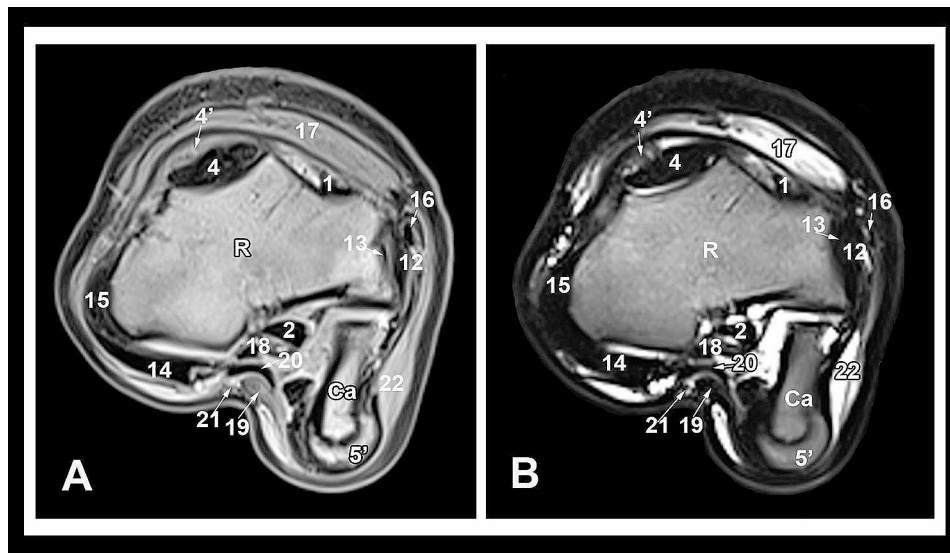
Transverse T1 (A) and T2-weighted (B) high-field MRI images at the level of the distal radius. Medial is to the left. R, radius; Ca, accessory carpal bone; 1, common digital extensor tendon; 2, deep digital flexor tendon; 4, radial carpal extensor tendon; 4', tendon sheath of the radial carpal extensor tendon; 5', origin of the superficial digital flexor tendon; 12, long lateral collateral carpal ligament; 13, proximal part of the short lateral collateral carpal ligament; 14, long medial collateral carpal ligament; 15, proximal part of the short medial collateral carpal ligament; 16, lateral digital extensor tendon; 17, extensor retinaculum; 18, radial carpal flexor tendon; 19, median artery; 20, median vein; 21, median nerve; 22, flexor retinaculum
